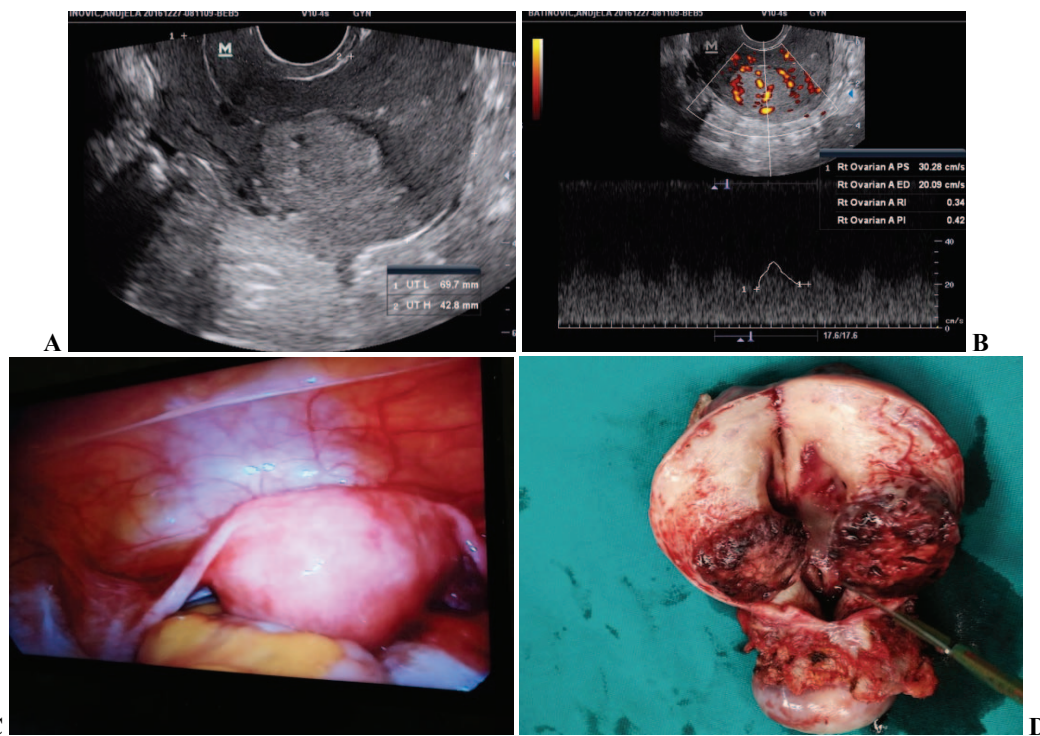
A) Uterus with gestational trophoblastic neoplasm (GTN): ultrasound finding; B) GTN: color Doppler flow; C) Uterus: laparoscopic view; D) Dissected uterus with GTN.
